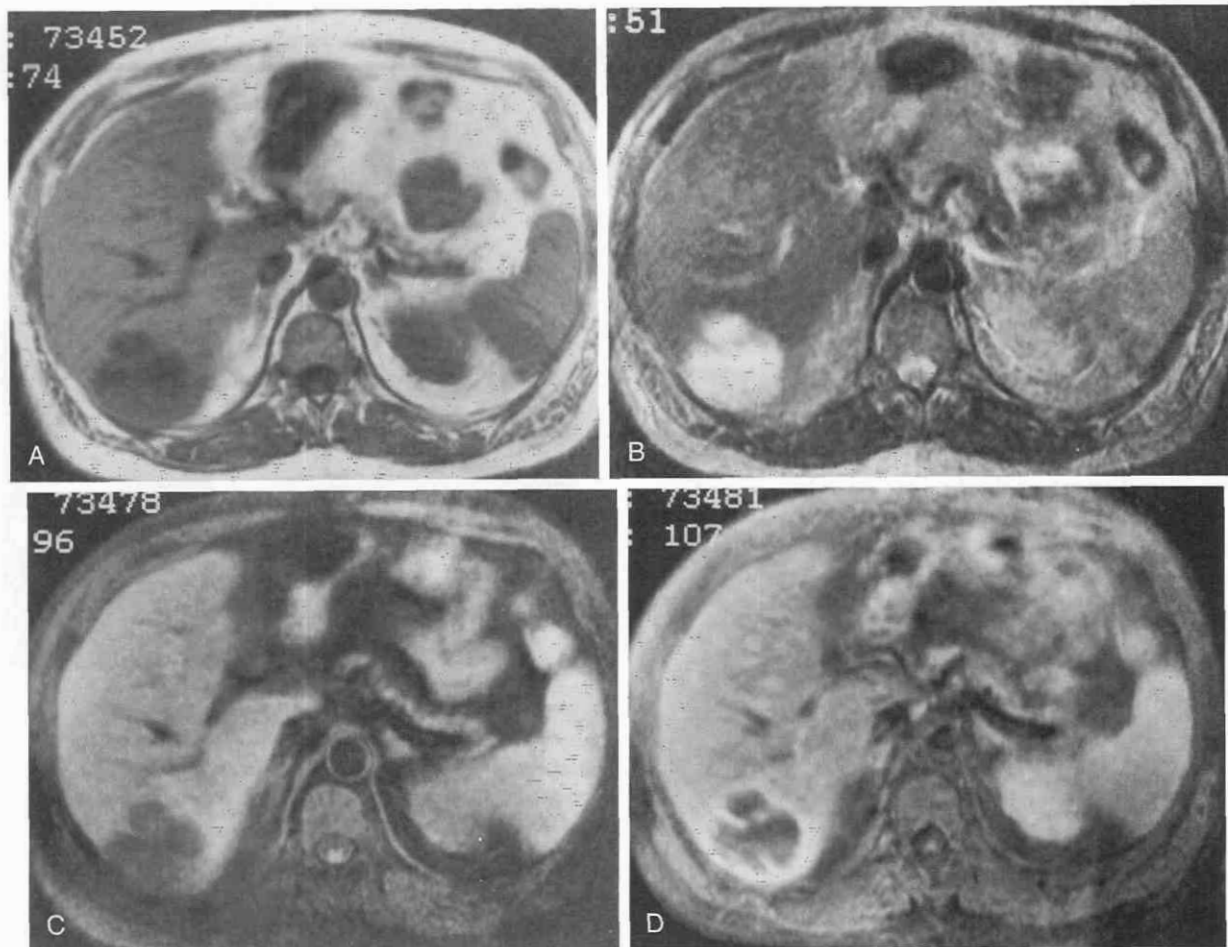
Amebic liver abscess in a 60-year-old man. *A*, T1-weighted image (TR = 300 msec, TE = 15 msec) demonstrates a lobulated, low-signal-intensity lesion of the posterior segment of the right hepatic lobe. *B*, T2-weighted image (TR = 2400 msec, TE = 90 msec) demonstrates the lesion to be of high signal intensity relative to the liver. The internal septa are of low signal intensity. *C*, Fat-suppression T1-weighted image (TR = 800 msec, TE = 15 msec) demonstrates the lesion continuing to be of low signal intensity. *D*, Fat-suppression T1-weighted image (TR = 800 msec, TE = 15 msec) after intravenous gadolinium (Gd-DTPA) demonstrates enhancement of the rim and internal septa.
